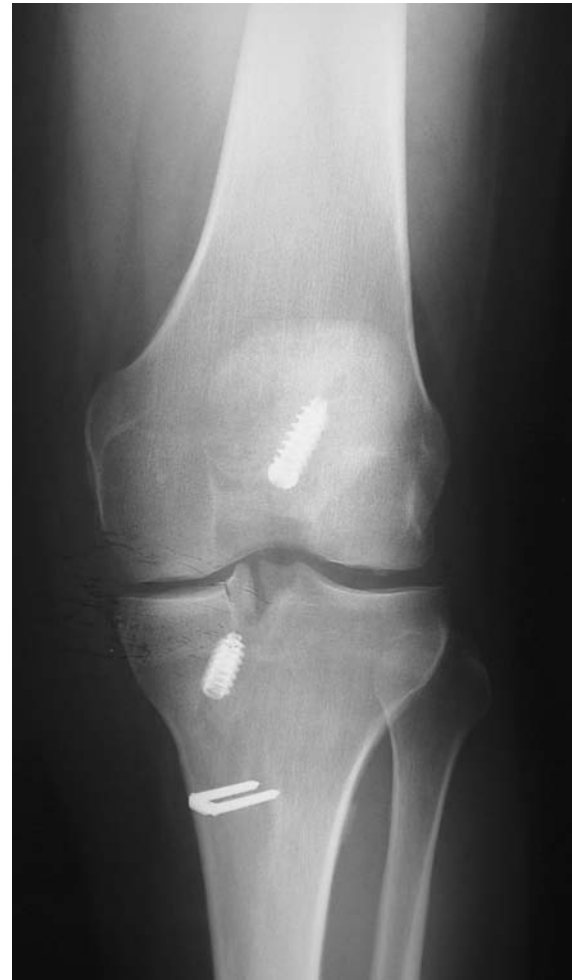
Postoperative radiograph (concomitant anterior cruciate ligament reconstruction).
